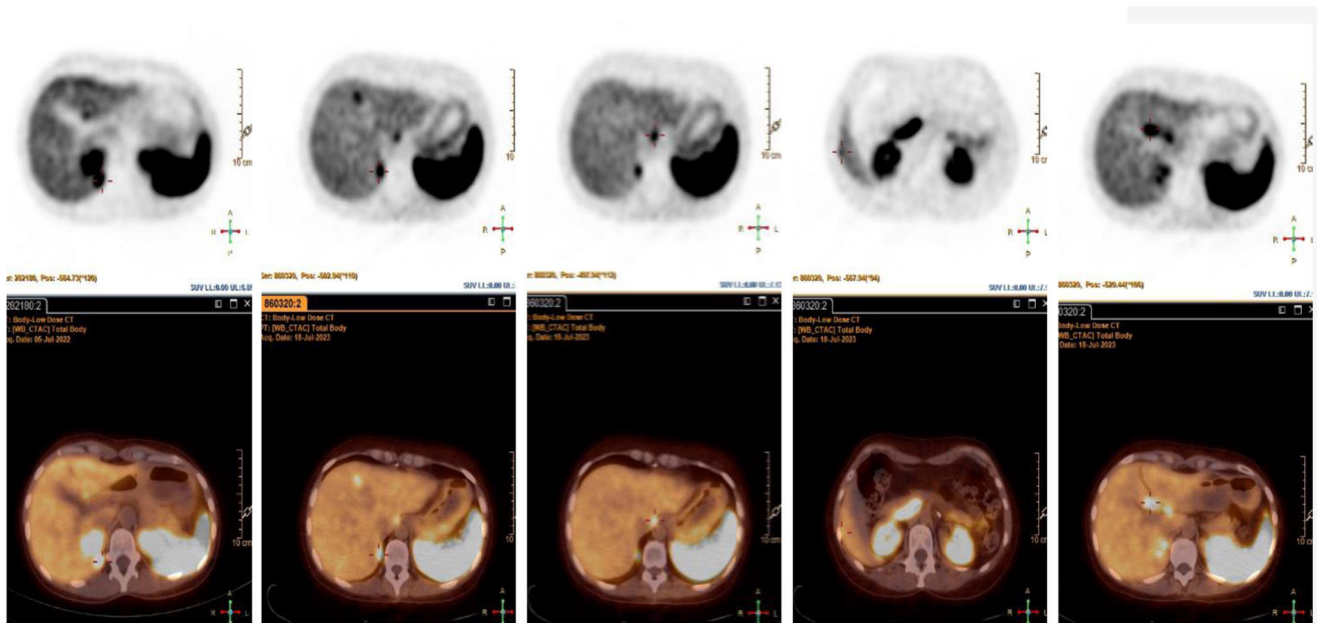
Functional imaging modality with evidence of metastatic disease. A ^{68}Ga -DOTANOC PET/CT was performed after biochemical persistence disease documentation following bilateral adrenalectomy. Radiotracer uptake was consistent with multiple metastatic foci expression in the following locations: right kidney posterior region, liver medial region, and anterior region of the right 12th rib; several peritoneal lesions were found on the right paravertebral and right pre-aortic perihepatic region and lateral liver surface (segment V/VI), along with multiple hepatic hilum foci, which may be adenopathies or peritoneal lesions.
